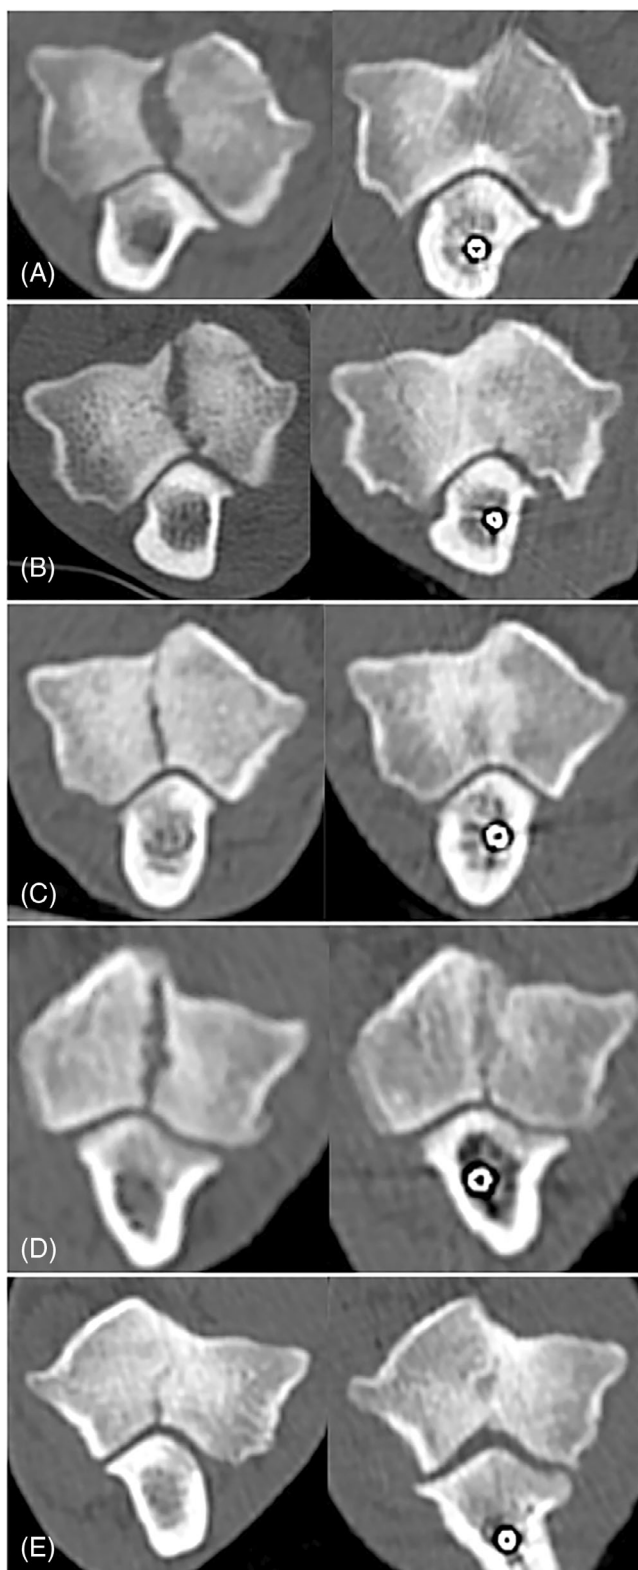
Examples of good healing of the fissure achieved by performing an oblique proximal ulnar osteotomy (PUO) (left column: preoperative computed tomographic (CT) images; right column: latest follow-up CT images). (A) A 6-month-old english springer spaniel (ESS) (A2: 10-month follow-up). (B) A 7-month-old ESS (B2: 10-month follow-up). (C) A 2-year-old ESS (C2: 18-month follow-up). (D) A 5-year and 8-month-old Cocker x Spaniel cross (D2: 20-month follow-up). (E) A 3-year and 8-month-old ESS (E2: 16-month follow-up).
